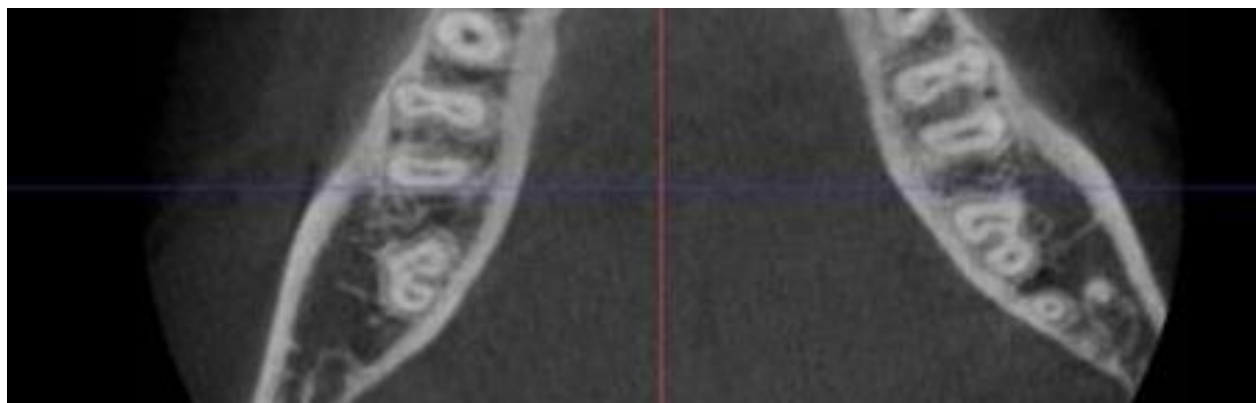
CBCT image of the mandibular second molars` C2-shaped canal (Bilateral)
